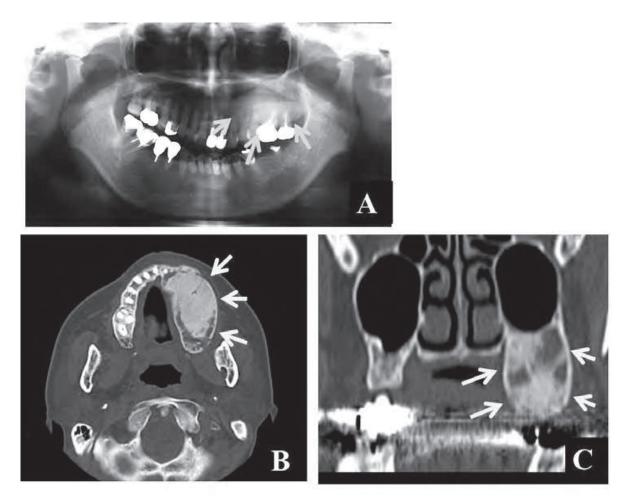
Panoramic radiograph image (A) and axial (B), coronal (C) CT images of fibrous dysplasia in left maxilla (arrows).
